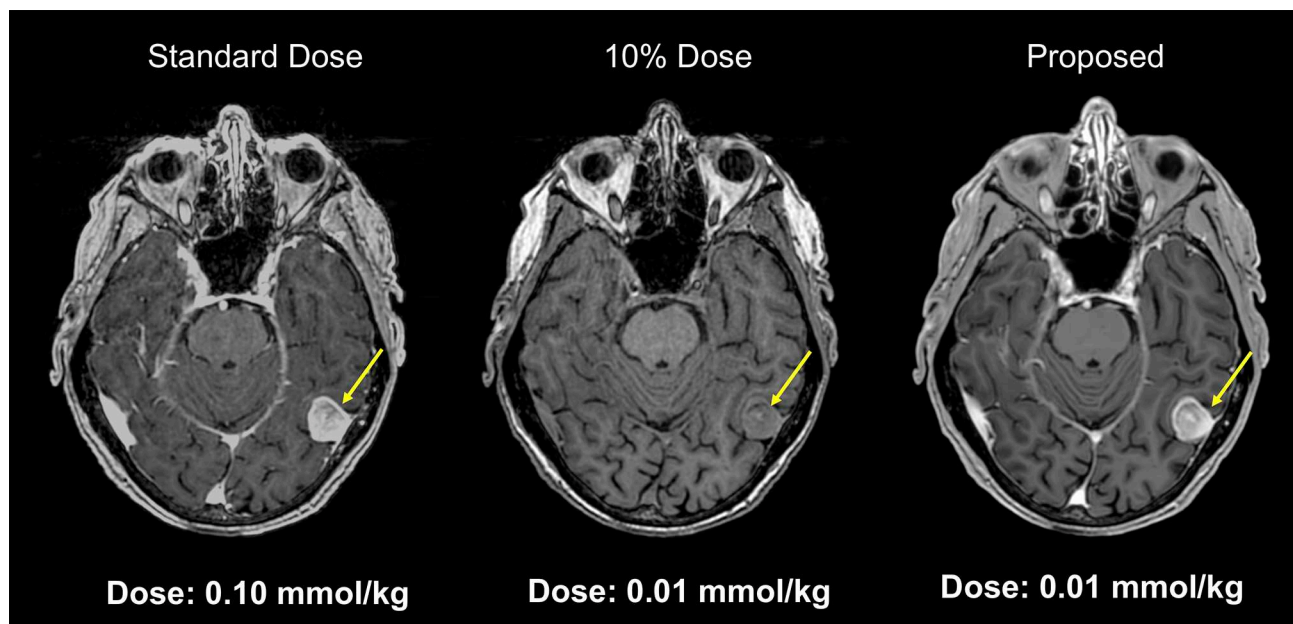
Example of low-dose contrast-enhanced MRI. Results from a deep network for predicting a 100% contrast dose image from a study obtained with 10% of the standard contrast dose. This example MRI is obtained from a patient with meningioma. Such methods may enable diagnostic quality images to be acquired more safely in a wider range of patients (Courtesy of Subtle Medical, Inc.).
